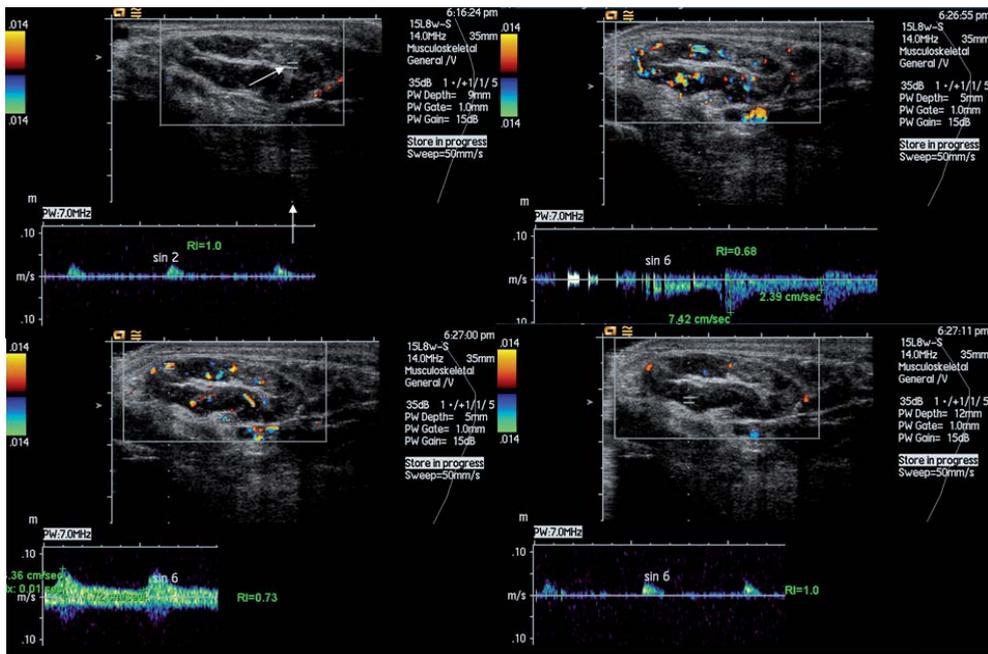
Resistive index (RI) before and after ischemia. The images are transverse scans of the left abductor hallucis muscle in a control subject. They are triplex scans meaning that grey-scale ultrasound is combined with color Doppler and spectral Doppler. Color Doppler is used to identify the vessels and guide the positioning of the Doppler line (vertical arrow) and the Doppler gate (oblique arrow). The spectral Doppler measurements are performed inside the gate (between the two horizontal lines). In the bottom of each image the spectral Doppler trace is seen. Top left is before ischemia. The Doppler trace shows only systolic flow and the RI is 1.0. Top right is the first RI-measurement after ischemia. Flow is seen throughout the cardiac cycle. The peak systolic and enddiastolic flows have been measured and the RI is 0.68. Bottom left is the second RI-measurement which is similar to the first. RI is 0.73. Bottom right is the third RI-measurement where the preischemic conditions seem reestablished. RI is again 1.0.
